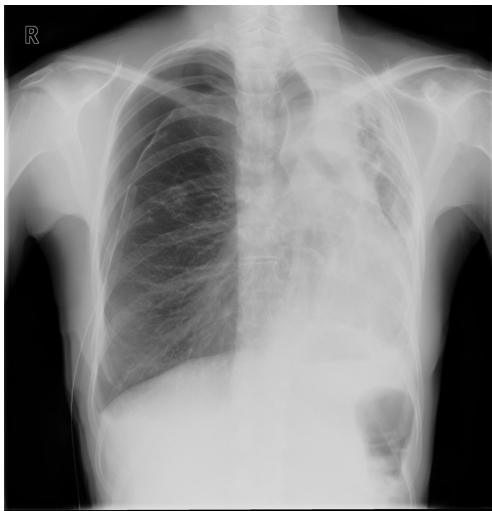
Chest radiograph after chest tube drainage showing persistent pneumothorax despite appropriate tube placement.
